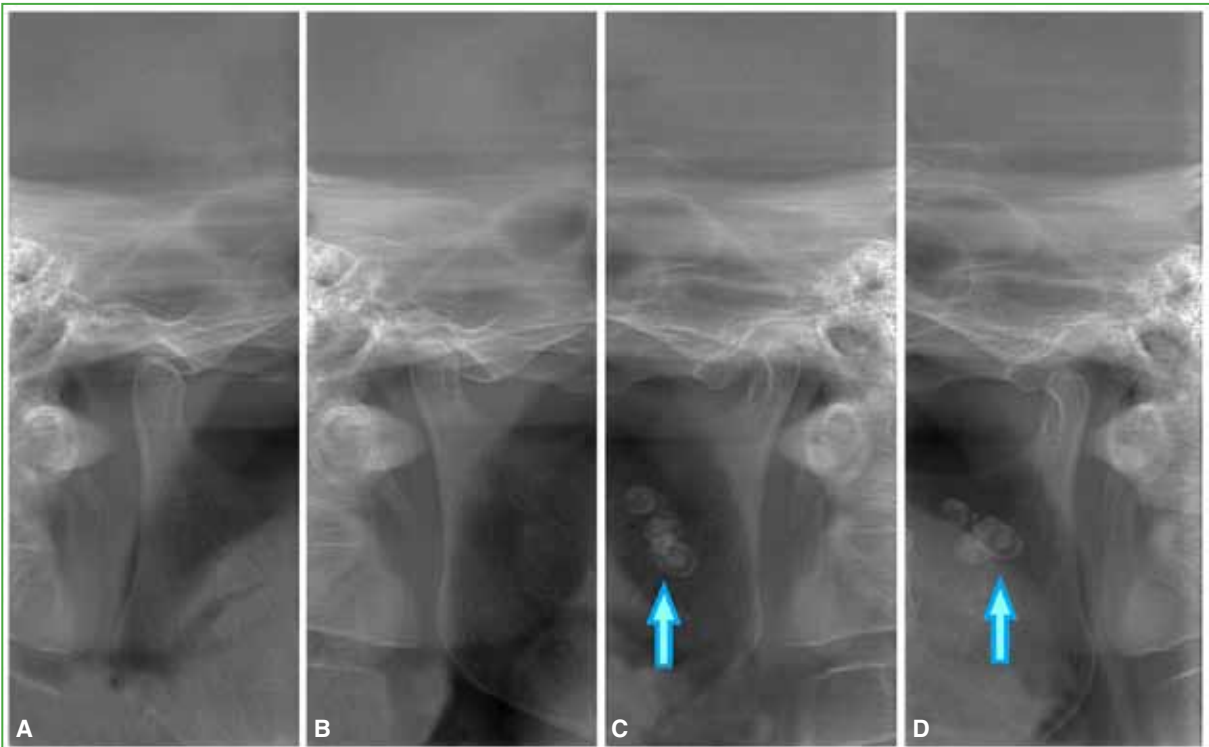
Radiograph of the temporomandibular joint. A. Right joint with open mouth. B. Right joint with mouth closed. C. Left joint with mouth closed. D. Left joint with open mouth.
